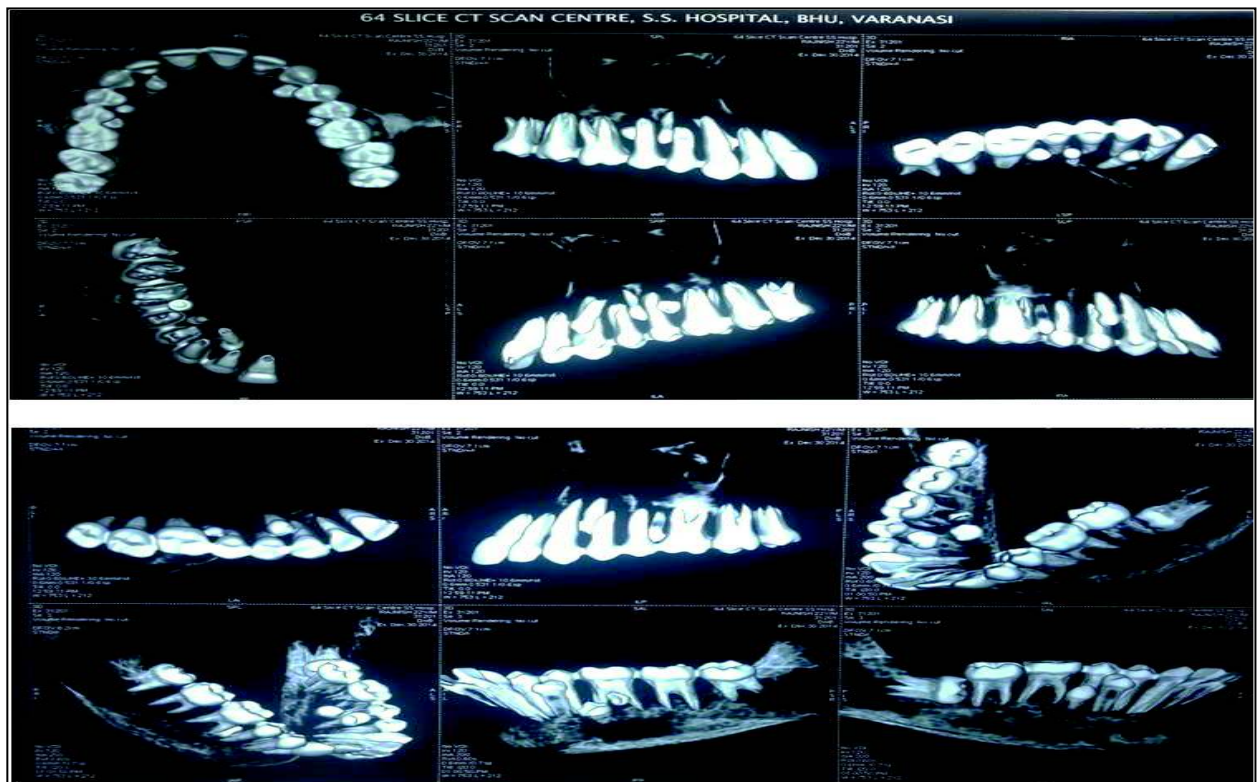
Computed tomogram
